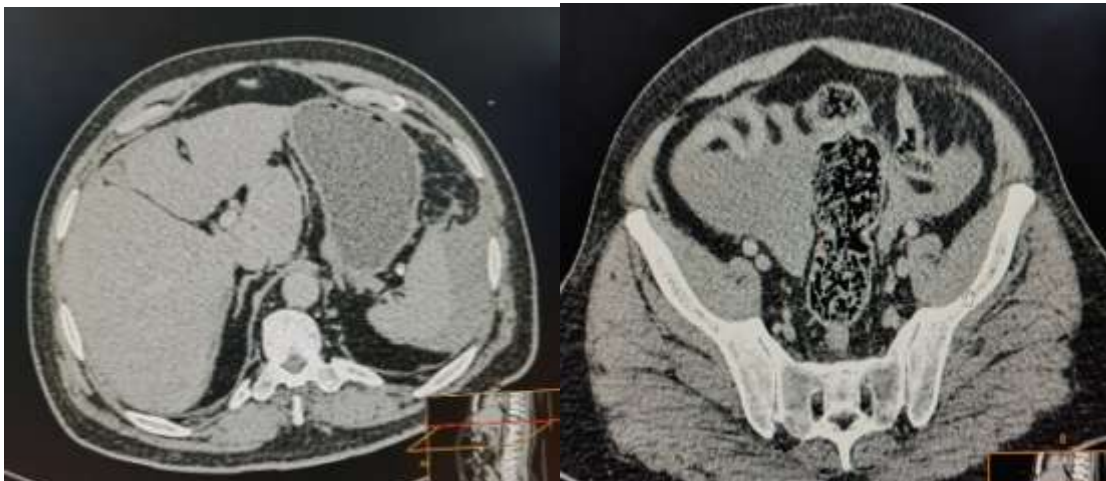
Abdominopelvic computed tomography showing moderate hemoperitoneum.
